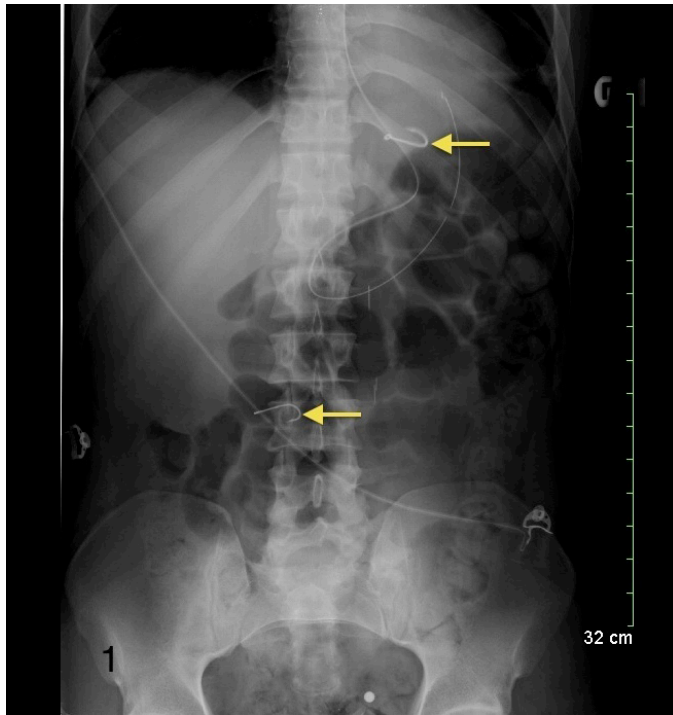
X-ray revealing one hook in the stomach near the gastroesophageal junction and another near the terminal ileum.
